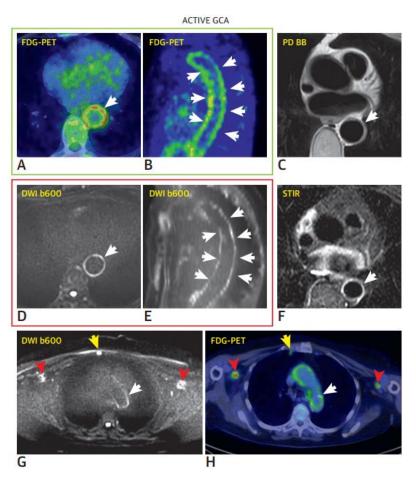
Patient with an active LVV of descending thoracic aorta, without ongoing glucocorticoid therapy. Pathological FDG-PET/CT study, A. Axial FDG-PET/CT, B. Sagittal FDG-PET/CT; Pathological MRI imaging; C. Arterial wall hyperintensity with mild wall thickening, D. Axial, E. Sagittal reconstruction, F. edema, G and H. Comparison of MRI and FDG-PET/CT, subclavian arteries (red arrowheads), right mammarian artery (yellow arrows), aorta (white arrows). Ironi G. et al. (2018) ⁽¹⁸⁾.
